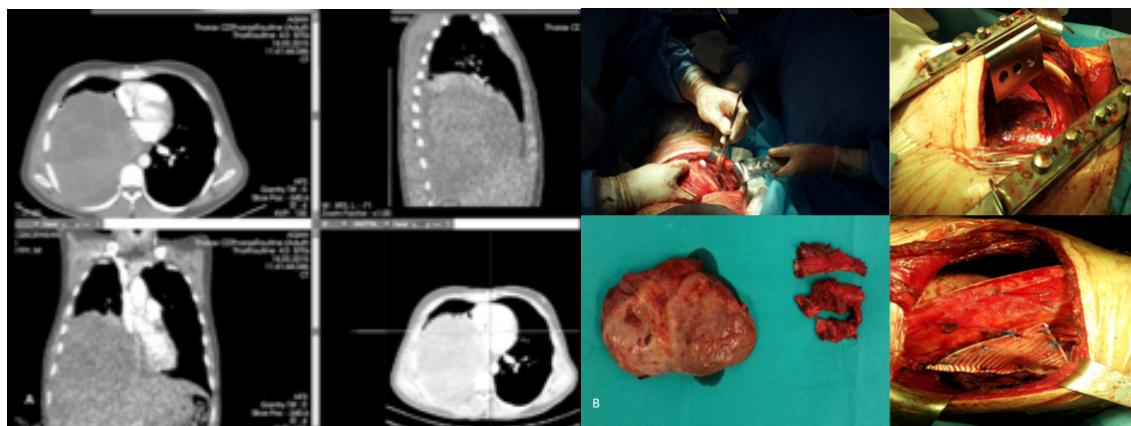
Thorax CT findings of a 19-year-old male patient. A 14 cm diameter tumor was seen in the right lower lobe causing compression on the heart and great vessels (A), Right thoracotomy and tumor excision with wedge resection and 9-10-11th rib resection was performed. A polypropylene mesh was used to repair the 10x15 cm chest wall defect (B).
